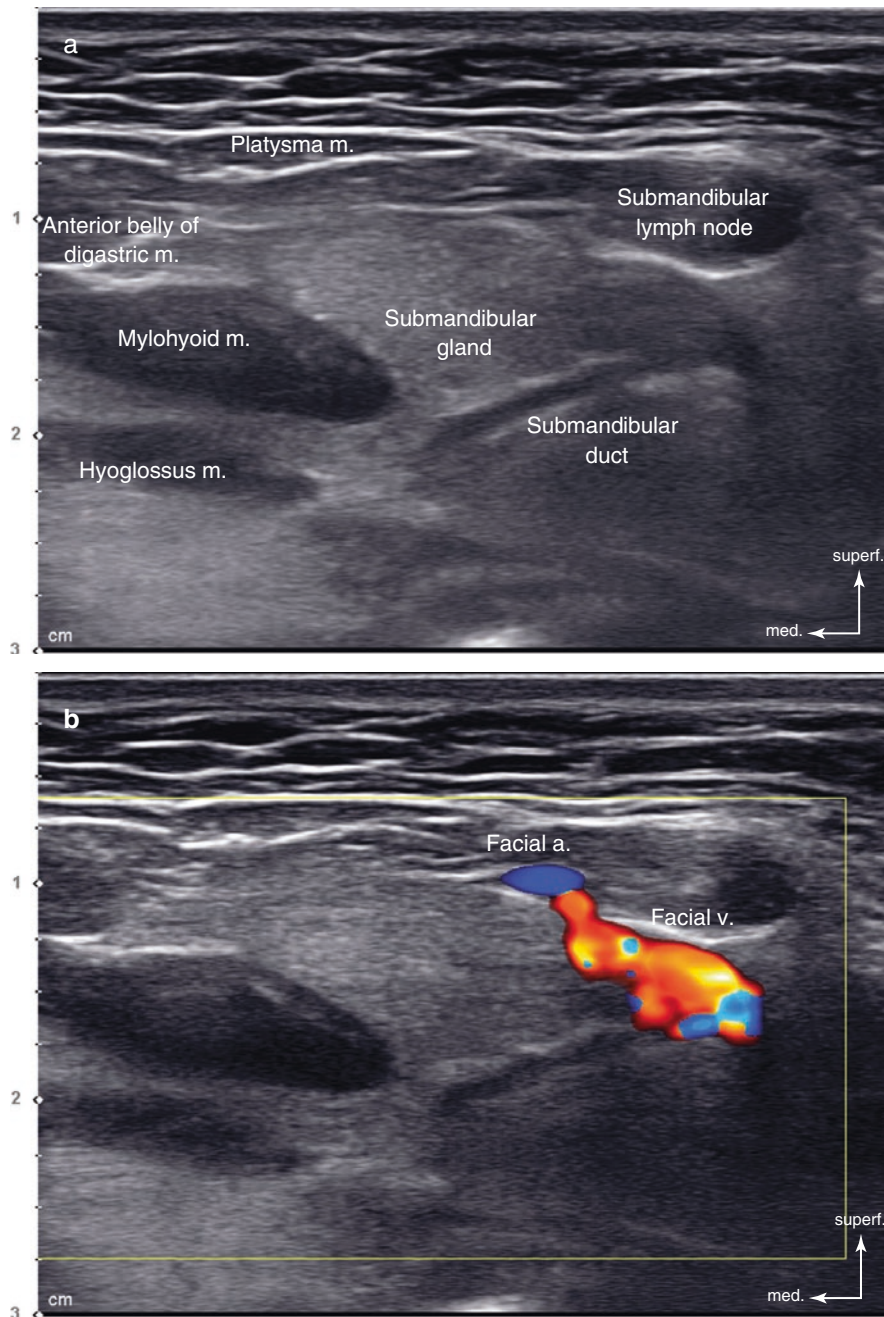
Ultrasonography of the submandibular triangle (C3). (a) B mode (transverse view, 15 MHz by linear transducer) and (b) Doppler mode (transverse view, 15 MHz by linear transducer). (Published with kind permission of © Hee-Jin Kim 2020. All Rights Reserved)
